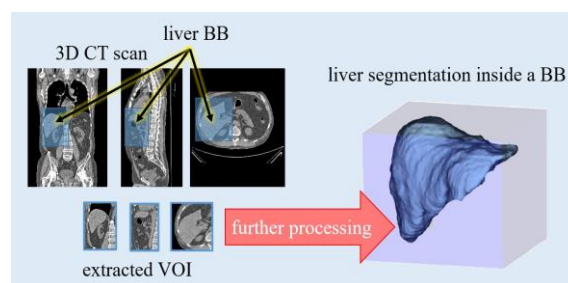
3D model of the liver inside a bounding box (right). Coronal, sagittal, and axial view of a CT scan with bounding box and extracted volume of interest (left).
